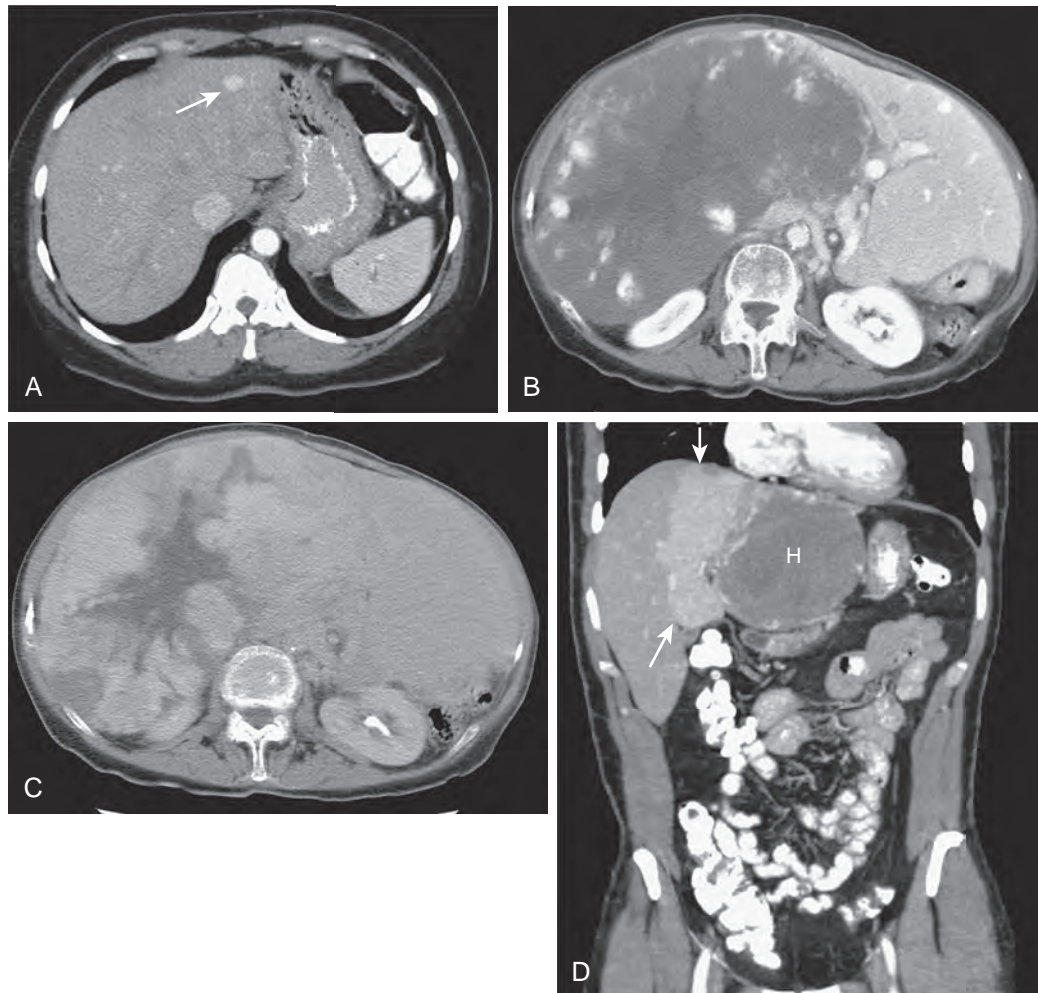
Hepatic hemangioma: CT features. A. Small hemangiomas (arrow) may demonstrate “flash filling” after intravenous administration of contrast material. The lesion, however, remains isodense with the blood pool, unlike focal nodular hyperplasia, adenoma, hepatoma, and hypervascular metastases, which may also show flash filling. B and C. Giant hemangioma, which replaces the right lobe, shows peripheral nodular enhancement that progresses in a centripetal fashion. The attenuation of the enhanced portions of the mass is isodense with the blood pool. The central portion of the lesion is a low-attenuation region of central fibrosis. D. This hemangioma (H) in the lateral segment of the left lobe is causing a transient hepatic attenuation difference (THAD) in the medial segment of the left hepatic lobe (arrows).
